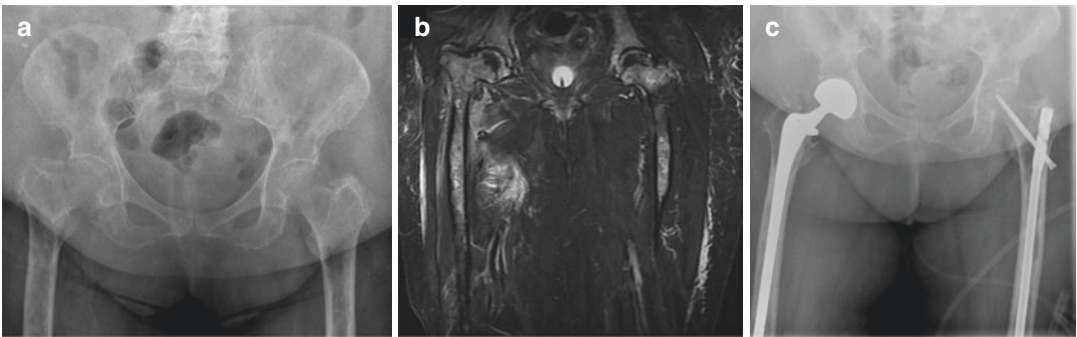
The 84-year-old woman with right complete fracture and left impending fracture due to metastatic breast carcinoma (a) preoperative radiograph. (b) Preoperative MRI. (c) Long-cemented prosthetic replacement to the right hip and long reconstruction nail fixation on the left femur
